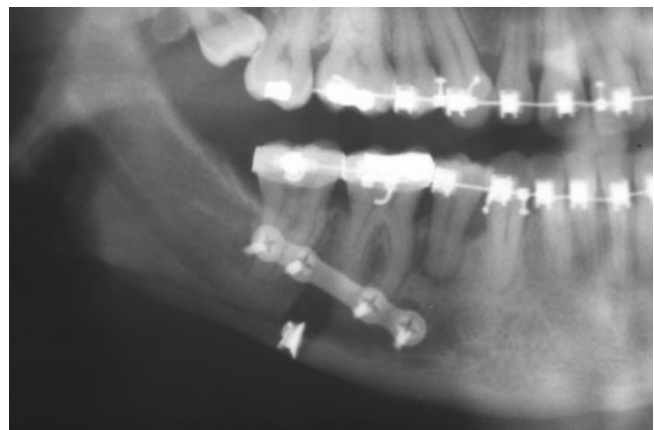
HF orthopantomogram
